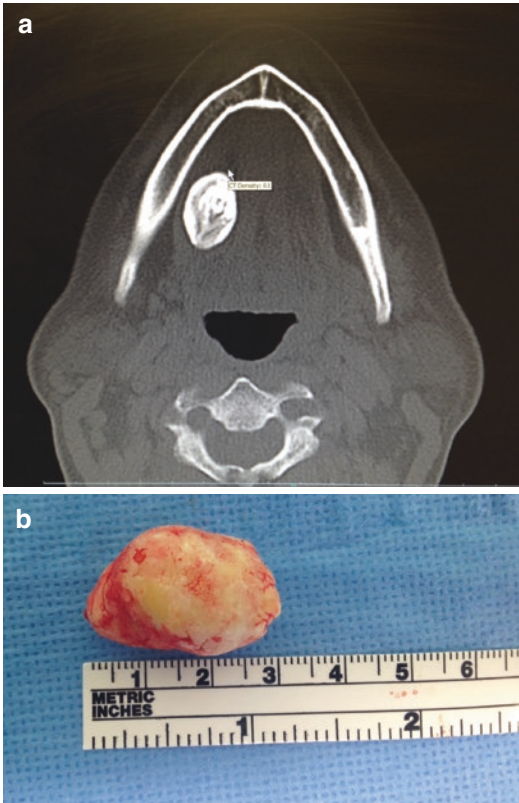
(a) CT scan showing a large right submandibular duct stone with hilar involvement. (b) Right submandibular duct “megalith”
